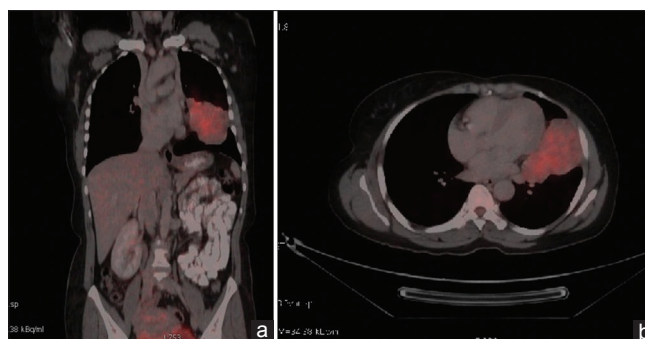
(a and b) Fluorine-18 fluorodeoxyglucose positron emission tomography-computed tomography shows an ill-defined mass measuring 76 mm × 62 mm × 17 mm in the left lower lobe (maximum standardized uptake value [SUVmax] 3.3)
